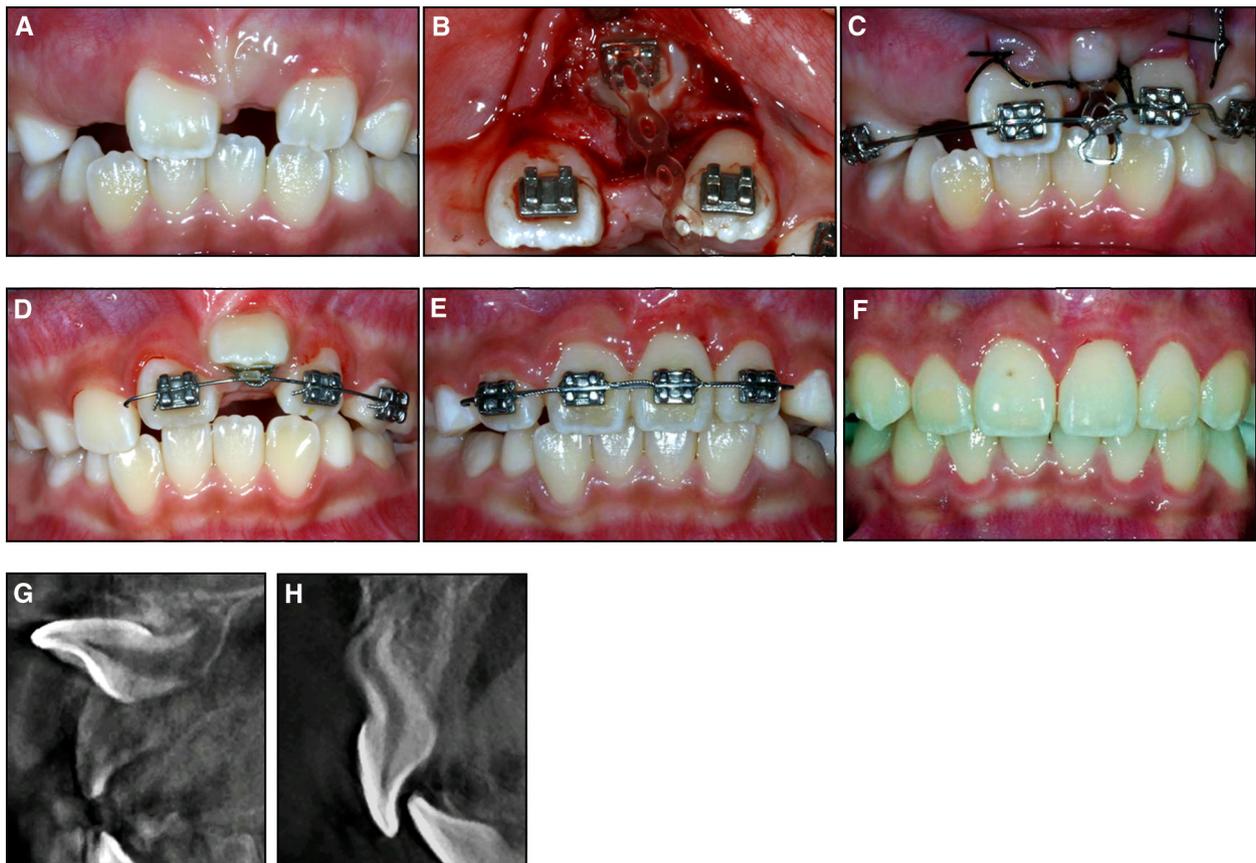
The patient was a girl, aged 6 years 10 months, with a unilateral osseous impacted immature maxillary central incisor: A, pretreatment view; B, surgical crown exposure showing the palatal surface; C, immediately postsurgical view; D, crown exposure caused by orthodontic traction force; E, the erupting incisor was properly aligned in the dental arch after 12.5 months of treatment, and the retention period started; F, final clinical aspect 1 year 10 months after the closed-eruption treatment; G, pretreatment CBCT; H, CBCT after the retention period.
